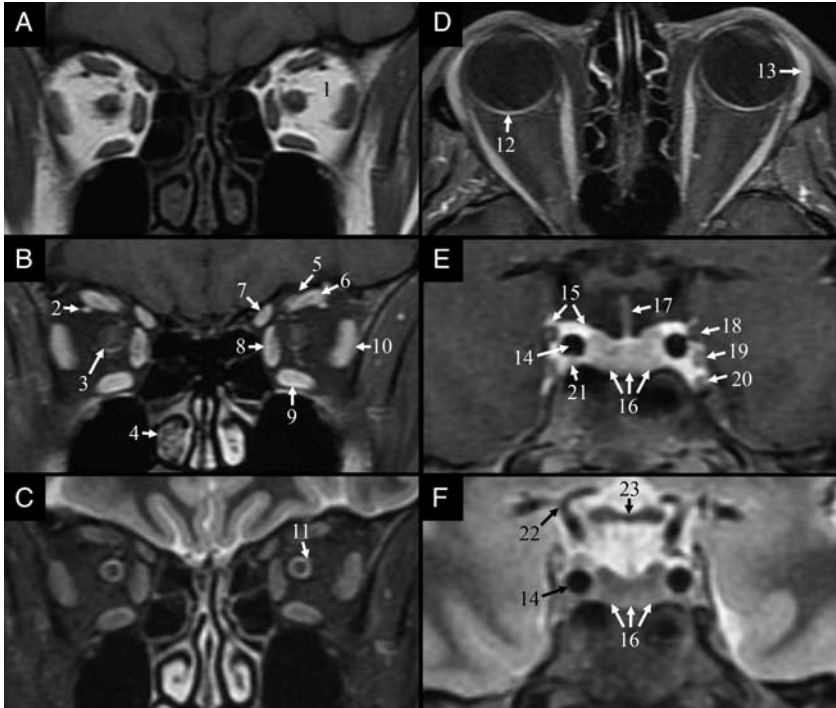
A, Coronal T1-weighted noncontrast-enhanced image through the mid orbits demonstrates normal anatomy; note the homogenous signal displayed by normal intraconal fat (1). B, Coronal T1-weighted contrast-enhanced fat-saturated image through the mid orbits demonstrates the enhancing superior ophthalmic vein (2), normal subtle enhancement of the optic nerve (3), and normal enhancement of the nasal mucosa which is often asymmetric (4). Also at this level, normal avid enhancement of the extraocular muscles is demonstrated including the levator palpebrae (5), superior rectus (6), superior oblique (7), medial rectus (8), inferior rectus (9), and lateral rectus (10). C, Coronal T2-weighted fat-saturated image through the mid orbits demonstrates normal signal intensity of the extraocular muscles as well as a layer of CSF within the optic nerve sheath, which can vary in thickness (11). D, Axial T1-weighted contrast-enhanced fat-saturated image through the mid orbits demonstrates the normal thin enhancing appearance of the ocular choroid (12) and the normal strong enhancement of the lacrimal gland (13). E, Coronal T1-weighted contrast-enhanced fat-saturated image through the cavernous sinus demonstrates the normal cavernous ICA flow void (14), normal enhancement in the cavernous sinus (15), normal hypoenhancement of the pituitary gland (16) relative to the adjacent cavernous sinus, and normal enhancement of the pituitary infundibulum (17) which appears bright compared to the surrounding CSF. Also at this level, several cranial nerves are constantly visible with nerves III-IV (18), VI (19), and V2 (20) along the lateral margin of the cavernous sinus and nerve VI (21) faintly visible in its more medial location. F, Coronal T2-weighted fat-saturated image through the cavernous sinus shows the ICA terminus (22), normal cavernous ICA flow void (14), and pituitary gland (16) which appears hypointense relative to adjacent cavernous sinus and CSF. The optic chiasm (23) is also well seen at this level and normally exhibits low signal intensity due to its high myelin content. CSF indicates cerebrospinal fluid.
